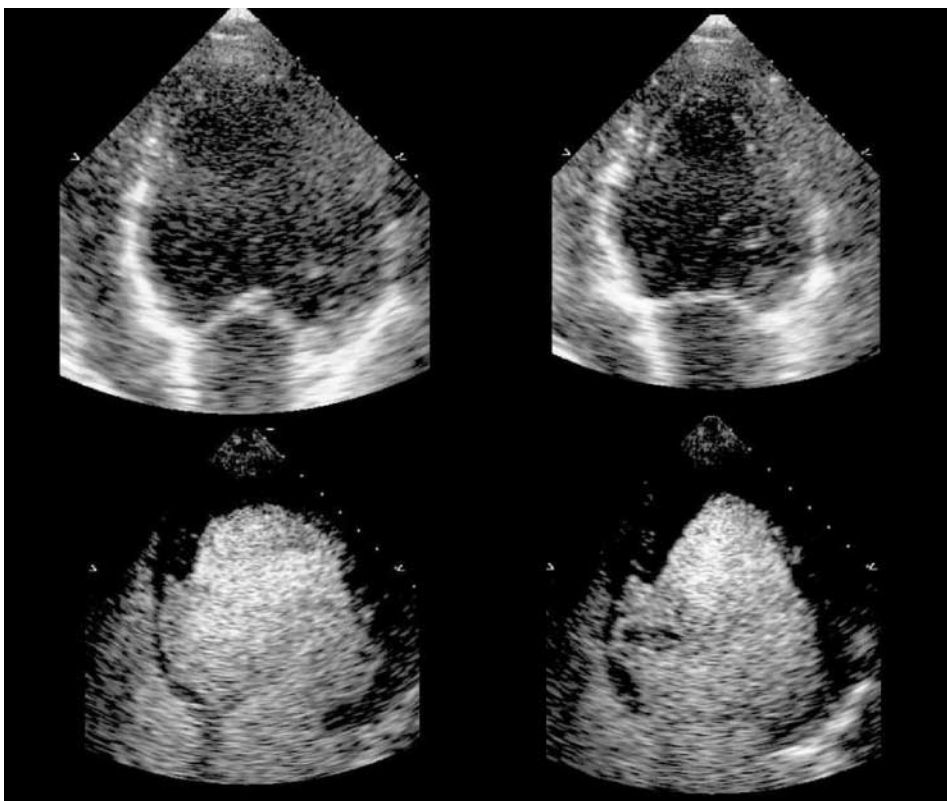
Transthoracic echocardiographic images (end-diastolic images left side, end-systolic images right side) of the apical four-chamber view obtained without (upper panels) and with administration of contrast agent using contrast specific low-mechanical imaging techniques (lower panels). While the endocardial border is not well seen at baseline it becomes readily visible with contrast enhancement.
